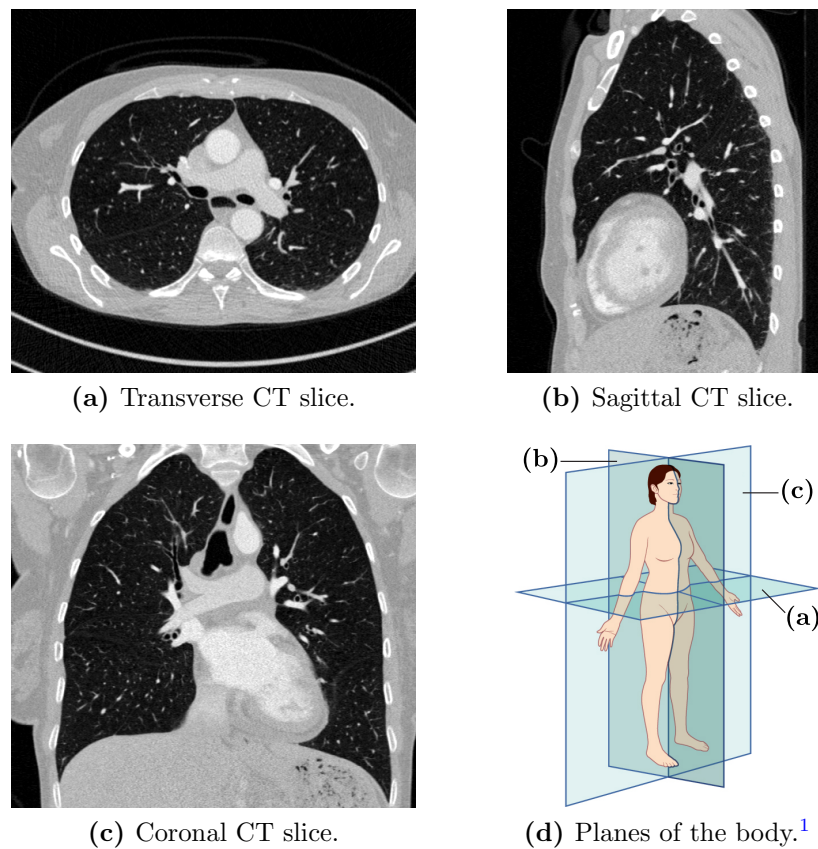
Example for different slices of a thoracic *CT* image. Image (a) shows a transverse, (b) a sagittal, and (c) a coronal slice of a thoracic *CT* image. Image (d) shows the orientation of the slices with respect to the human body.
